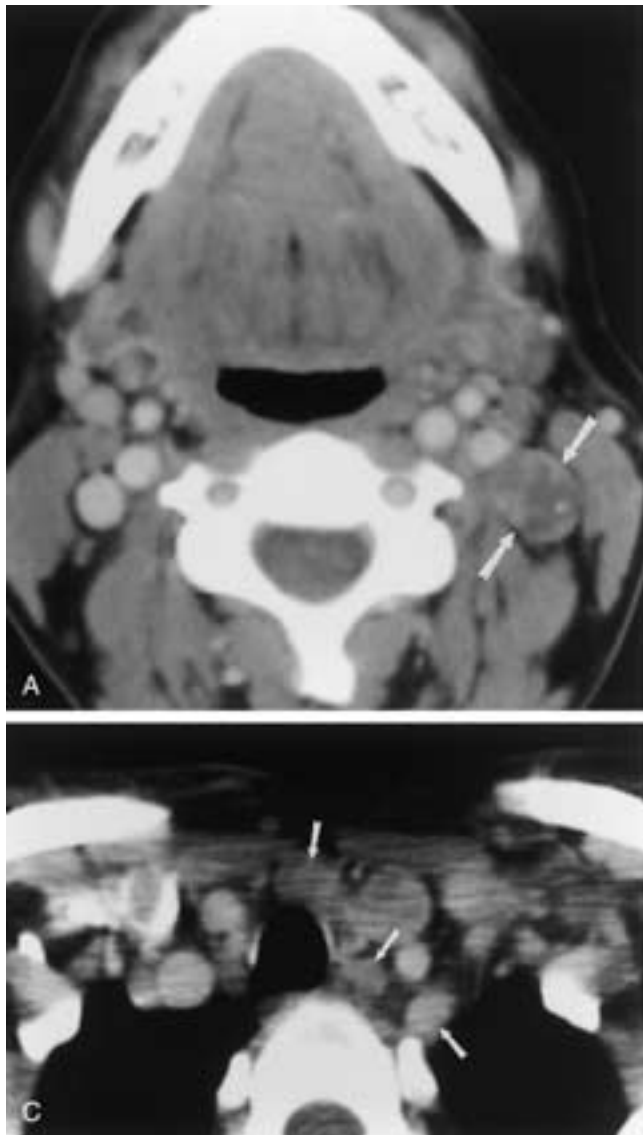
A 41-year-old woman presented with a palpable neck mass found to represent metastatic papillary carcinoma in a lymph node. A, Enhanced axial CT scan shows a low-density pathologic cervical lymph node (*arrows*). B, CT image obtained at the level of the thyroid gland shows no dominant mass; however, there is diffuse heterogeneous low density of the gland that represented infiltrative papillary carcinoma at pathology. Note the pathologic but normal-sized node (*arrow*). C, Image obtained just below the thyroid gland demonstrates central compartment nodal disease (*arrows*).
